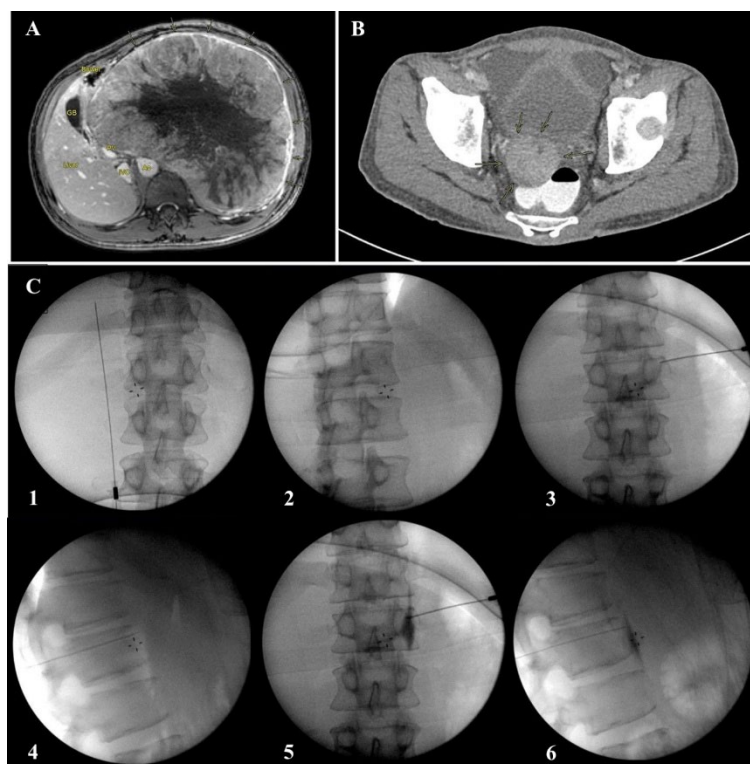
A) MRI of the abdomen showed a huge left retroperitoneal mass (yellow arrows) occupying most of the space within the abdomen. The mass displaces and compresses the aorta (Ao), inferior vena cava (IVC), portal vein (PV), liver, gallbladder (GB), and bowel, as seen in this figure. B) Contrast-enhanced computed tomography (CT) of the pelvis post-treatment showed a new enhancing mass anterior to the rectum (yellow arrows). This mass was not previously seen and indicates disease progression. C) Real-time images obtained during the CPB procedure by using C-arm Image Intensifier (II) 1) 12th rib, L1 vertebral body and transverse process identified (AP view) 2) 12th rib, L1 vertebral body and transverse process identified (lateral view) 3) Needle introduced by using right-sided posterior approach along the L1 vertebral body 4) Tip of needle bypasses the anterior border of L1 vertebral body 5) Contrast material used to visualize abdominal aorta border (AP view) 6) Contrast material used to visualize abdominal aorta border (lateral view)
